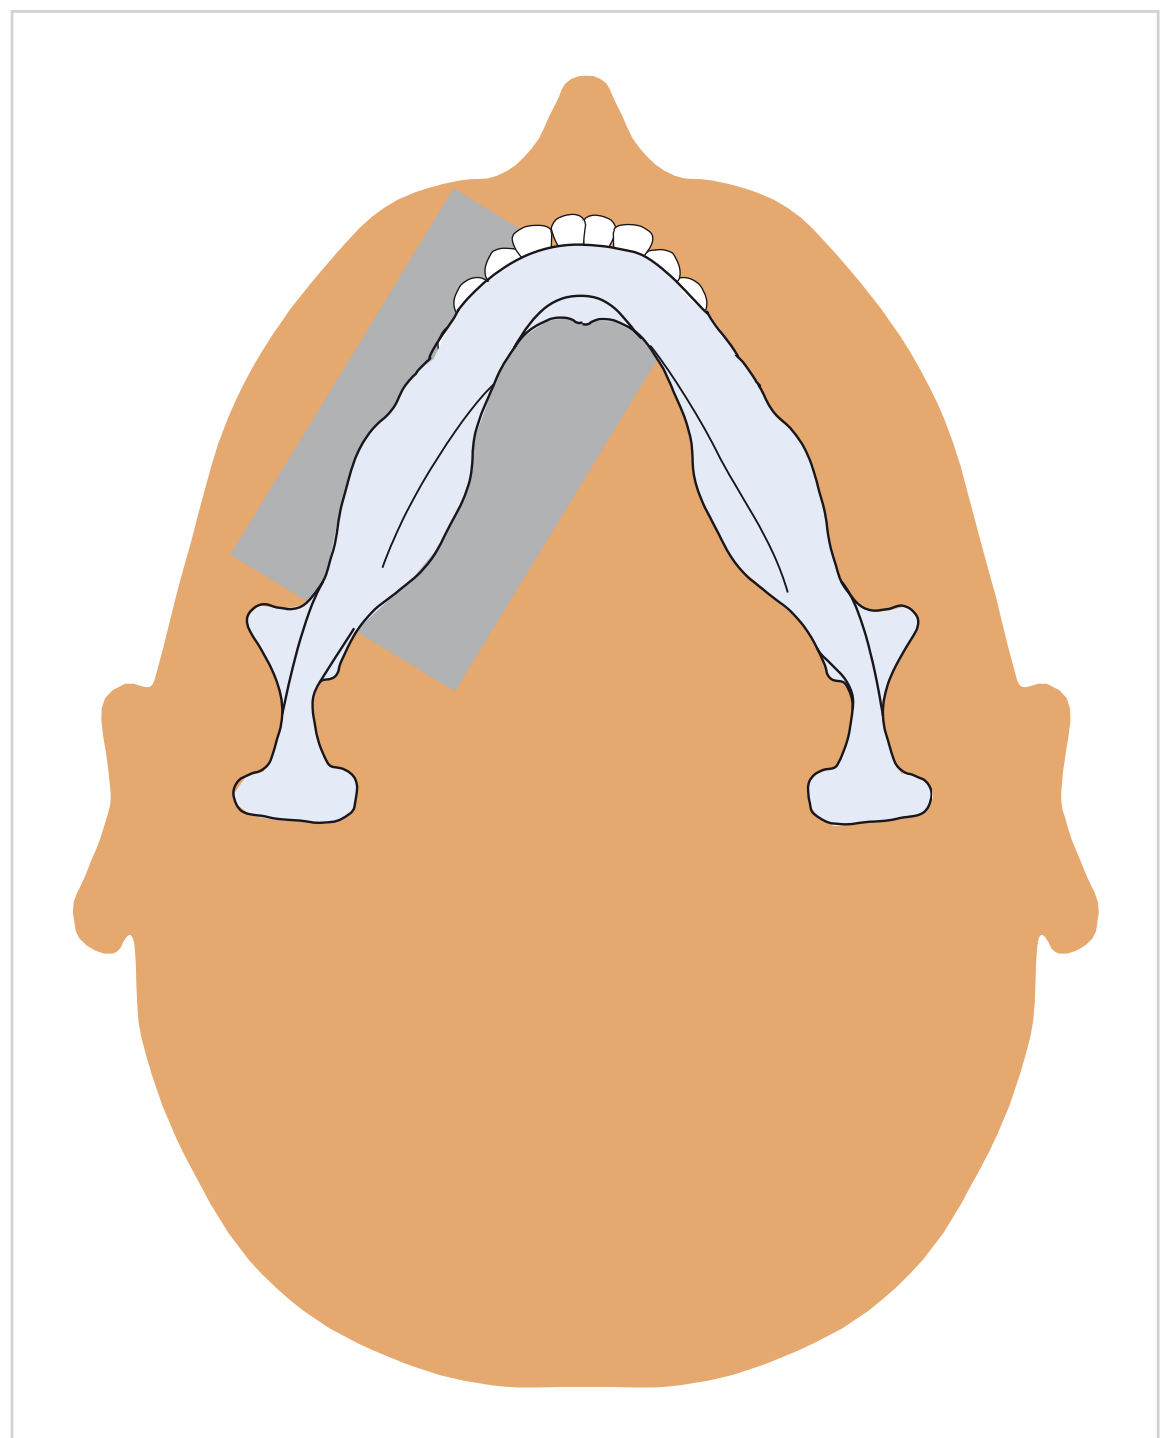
Correct positioning for occlusal radiography of the mandibular posterior teeth using the axial projection technique.
